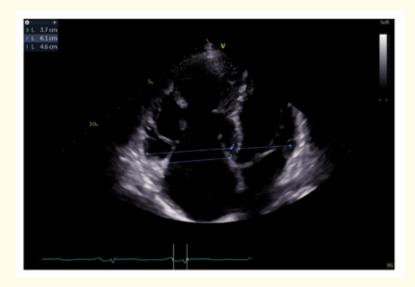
Transthoracic Echocardiography, Apical four chamber view showing right chamber dilation with a RV/LV diameter ratio of 1.64 with paradoxal septal motion. RV*: Right ventricle; LV*: Left ventricle.
